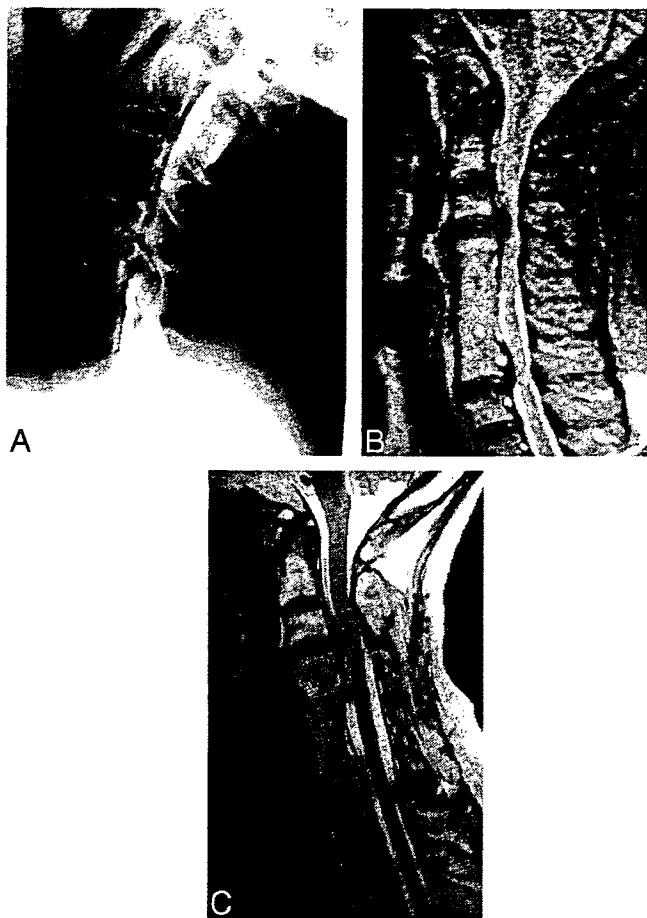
A female patient had undergone anterior cervical decompression and fusion (ACDF) from C5–C7 for cervical myelopathy resulting from soft disc herniation when she was 58 years old. She developed another disc herniation at C4–C5 2 years later and had ACDF again. At the age of 66 years, she developed cervical myelopathy again resulting from disc herniation at the adjacent segment (C3–C4), which was treated by expansive laminoplasty from C3–C7. She had moderate neurologic recovery after surgery (pre- and postoperative JOA scores 10 and 14, respectively). (A) Myelogram before the second surgery. (B) Magnetic resonance image before ELAP (T2-weighted sagittal image). (C) Magnetic resonance image at 9 years after ELAP (T2-weighted sagittal image). Although disc herniation at C3–C4 was still present, the spinal cord was nicely decompressed.
